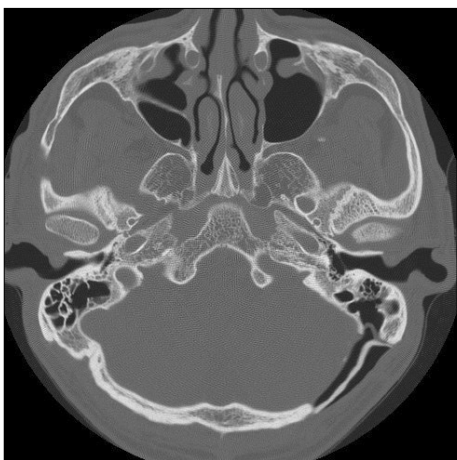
Axial computed tomography scan performed at 4 months after surgery shows increased pneumatocele and subgaleal air collection.
